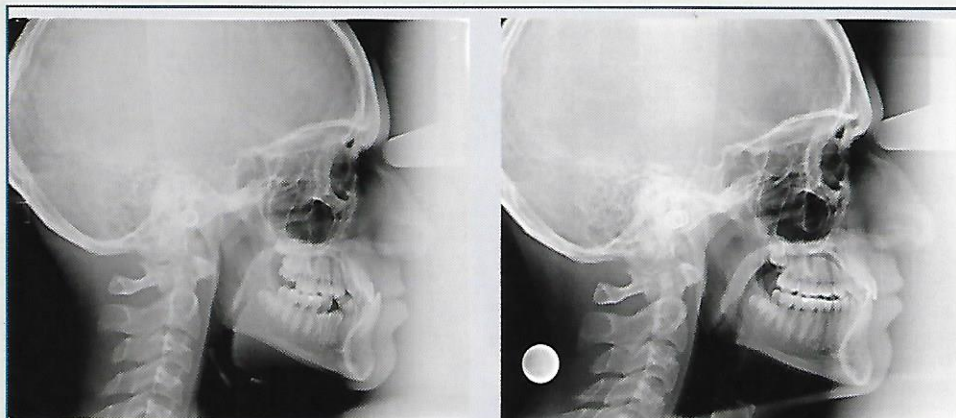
The left image is a pre-treatment cephalometric radiograph; the right image is a post-treatment cephalometric radiograph.
